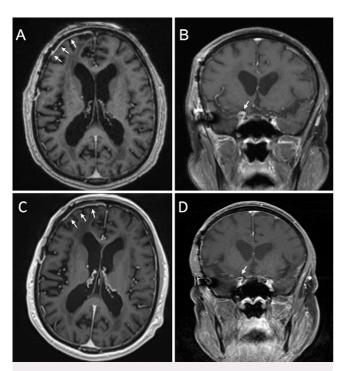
Postoperative and post-antibiotic T1-weighted post-gadolinium MRI scans demonstrate significant radiographic improvement of dural enhancement. Postoperative and post-antibiotic T1-weighted post-gadolinium MRI scans at 6 weeks in axial (A) and coronal (B) sections demonstrate significant improvement of dural enhancement (*arrows*). Repeat MRI at 6 months after surgery (C and D) demonstrates continued improvement of dural enhancement (*arrows*).
